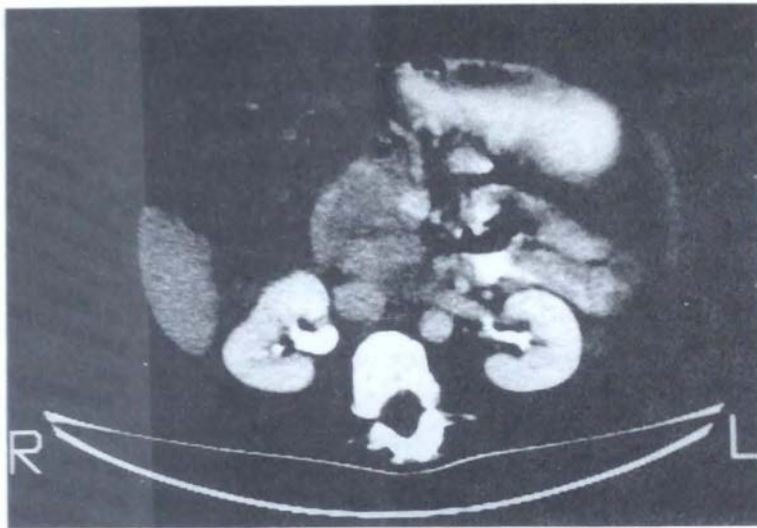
X-ray computed tomogram (CT) of the abdomen of a 40-year-old female patient. She presented with a preliminary diagnosis of gastric ulcer, but endoscopic biopsy of the stomach wall suggested cancer instead. The CT examination of the abdomen was performed to determine whether the stomach was indeed the primary tumor site. This is an image of the lower abdomen in transverse section; a large mass is seen in the center of the image, which has slightly displaced other organs from their normal position. This mass was later determined to be a pancreatic adenocarcinoma that had invaded the stomach wall and the duodenum, so stomach cancer was secondary to the primary cancer in the pancreas. Note the paired bean-shaped kidneys flanking the spinal column at the bottom of the image, the bright mass of the stomach lying obliquely at the upper right of the image, and the liver to the left of the tumor mass. (Photograph courtesy of Dr. Charles Rohrmann and Dr. James A. Nelson, University of Washington School of Medicine.)
